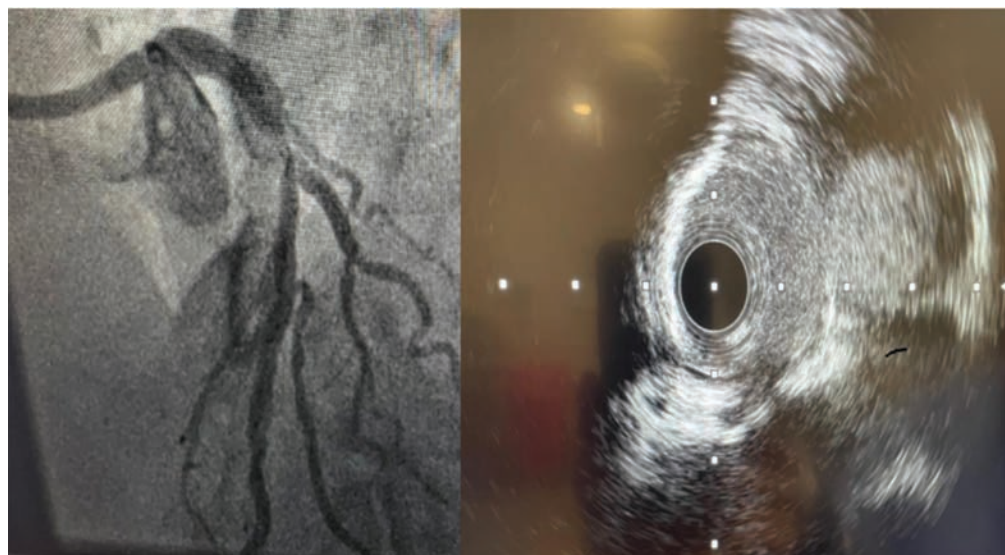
Bifurcation lesion. Left anterior descending (LAD)/diagonal stenosis. Intravascular ultrasound (IVUS) revealed calcific disease in the LAD and a normal diagonal artery. IVUS shows eccentric superficial disease (blue arrow) and a deeper component (white arrow) that was successfully treated with intravascular lithotripsy (IVL), noncompliant (NC) balloon, and provisional LAD drug-eluting stent (DES).
